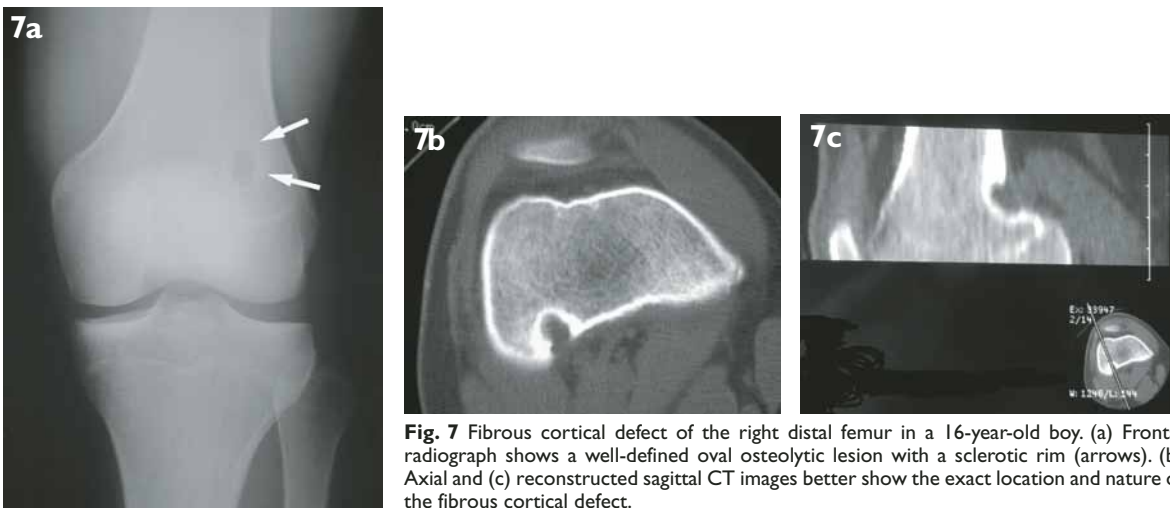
Fibrous cortical defect of the right distal femur in a 16-year-old boy. (a) Frontal radiograph shows a well-defined oval osteolytic lesion with a sclerotic rim (arrows). (b) Axial and (c) reconstructed sagittal CT images better show the exact location and nature of the fibrous cortical defect.
